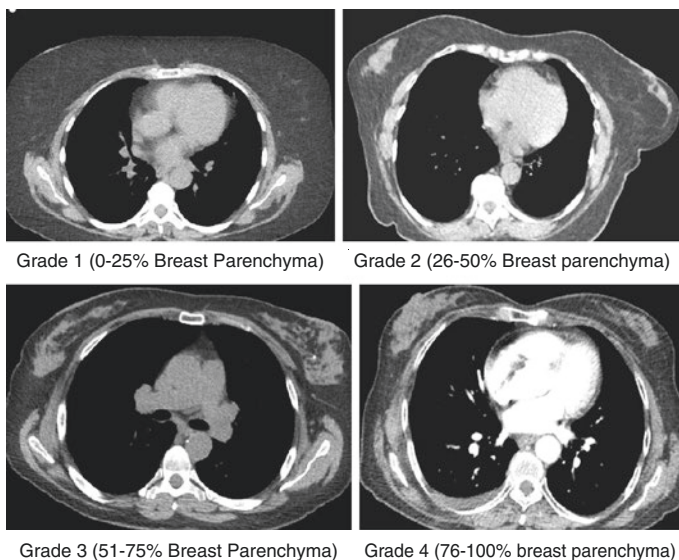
Breast density on chest CT
